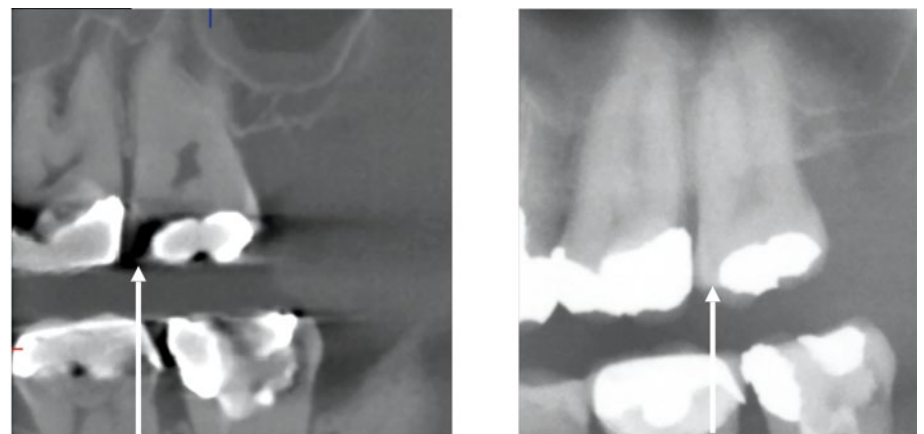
Left image – parasagittal CBCT slice of 26 and 27 showing lucency (secondary caries?) at the mesial aspect of 27. Right image – DPT from the same day showing 27 mesial aspect is sound
